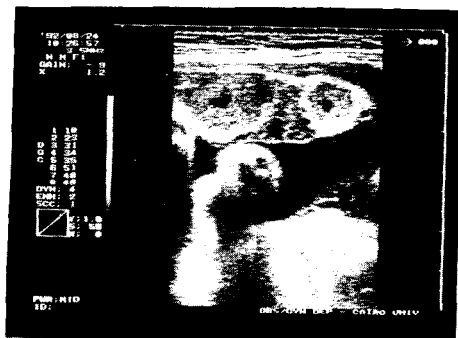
Real-time sonogram of grade III Placenta.
